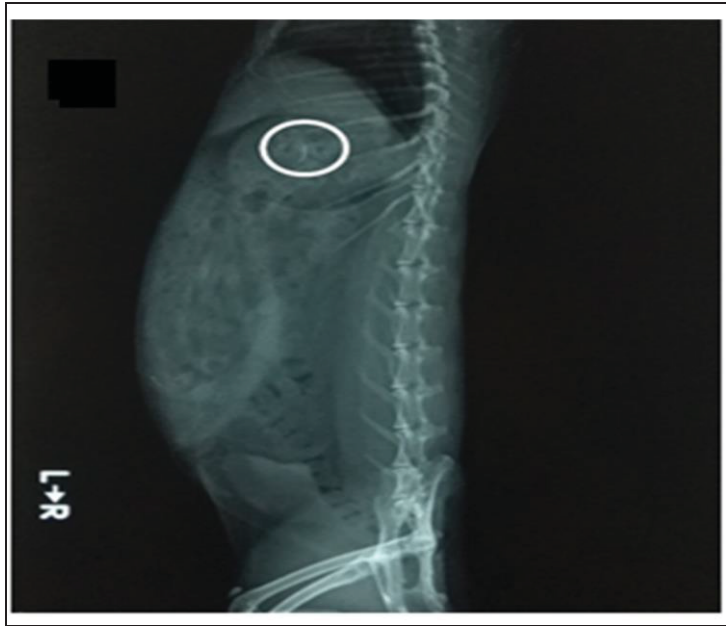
X-ray imaging radiograph at 2 hours
